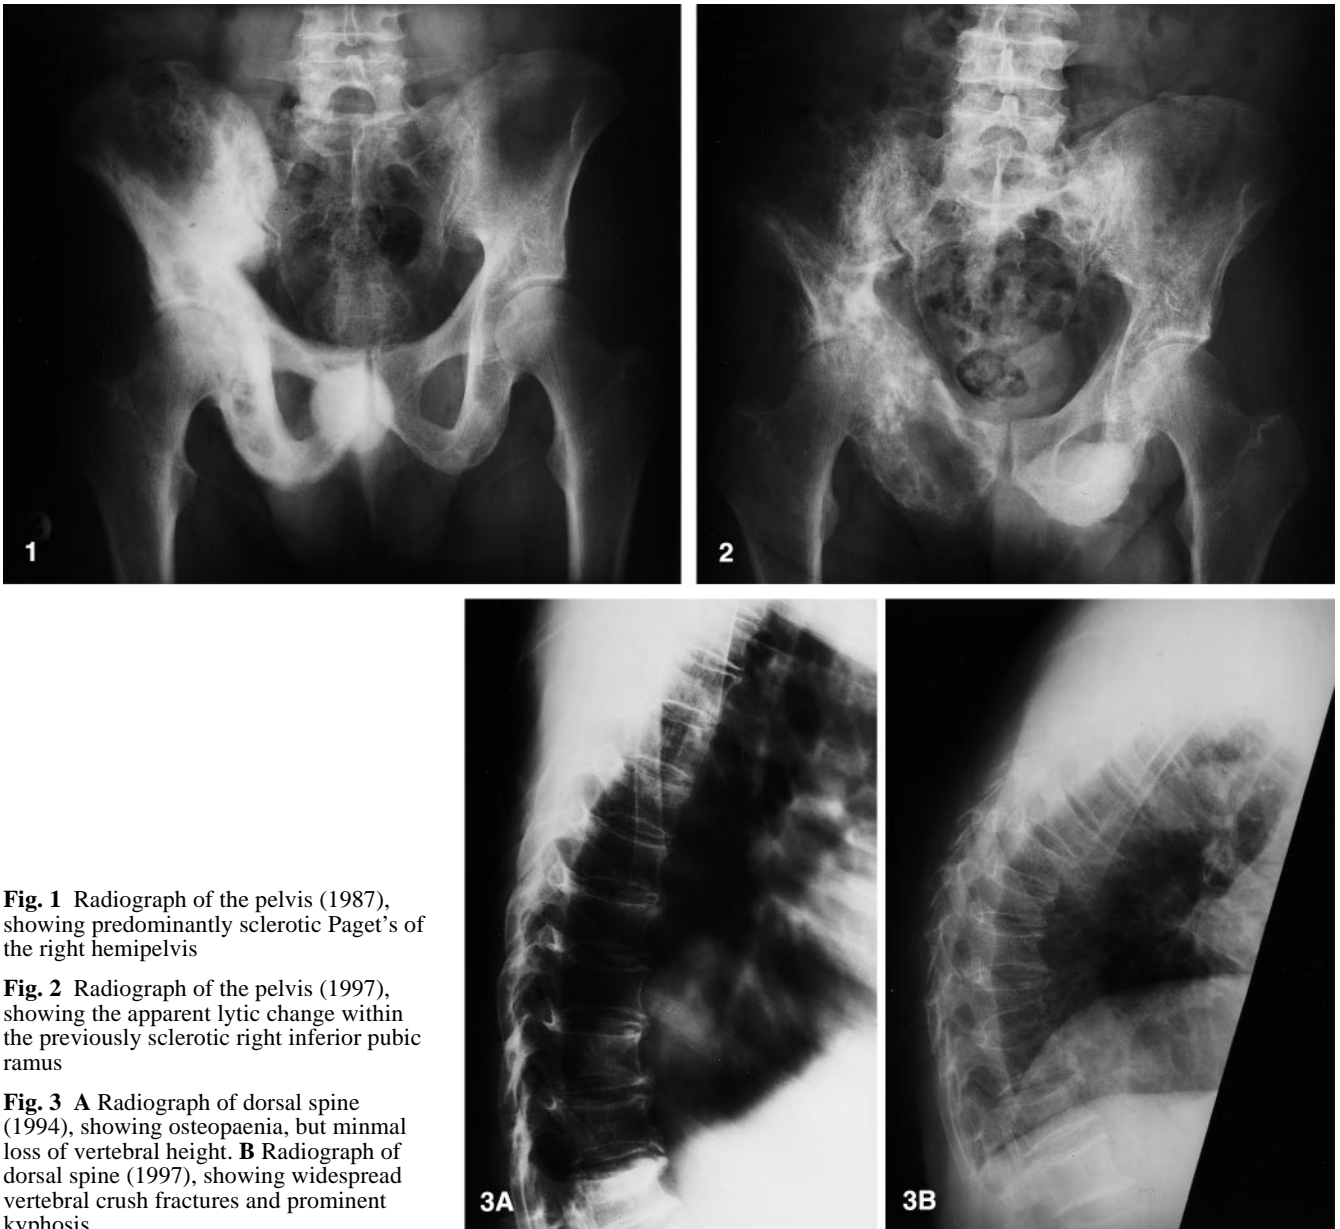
Radiograph of the pelvis (1987), showing predominantly sclerotic Paget's of the right hemipelvis
